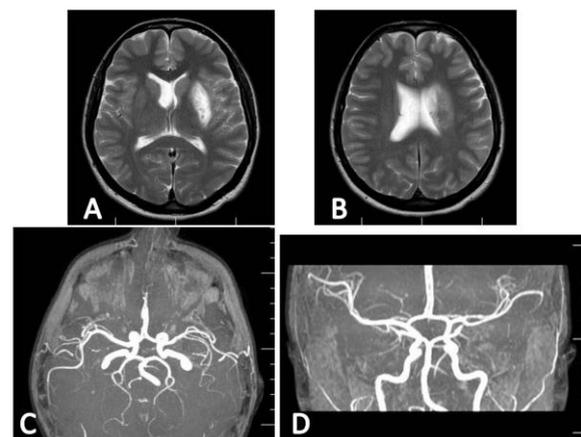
Figure IIIa-d. Although MRS: 0 at the time of discharge in 12 days, it was observed in the control MRG FLAIR sequences (a-b) that the observed damage at the first arrival continued, and in MRA (c-d) no problem was observed in the recanalized left OSA.
